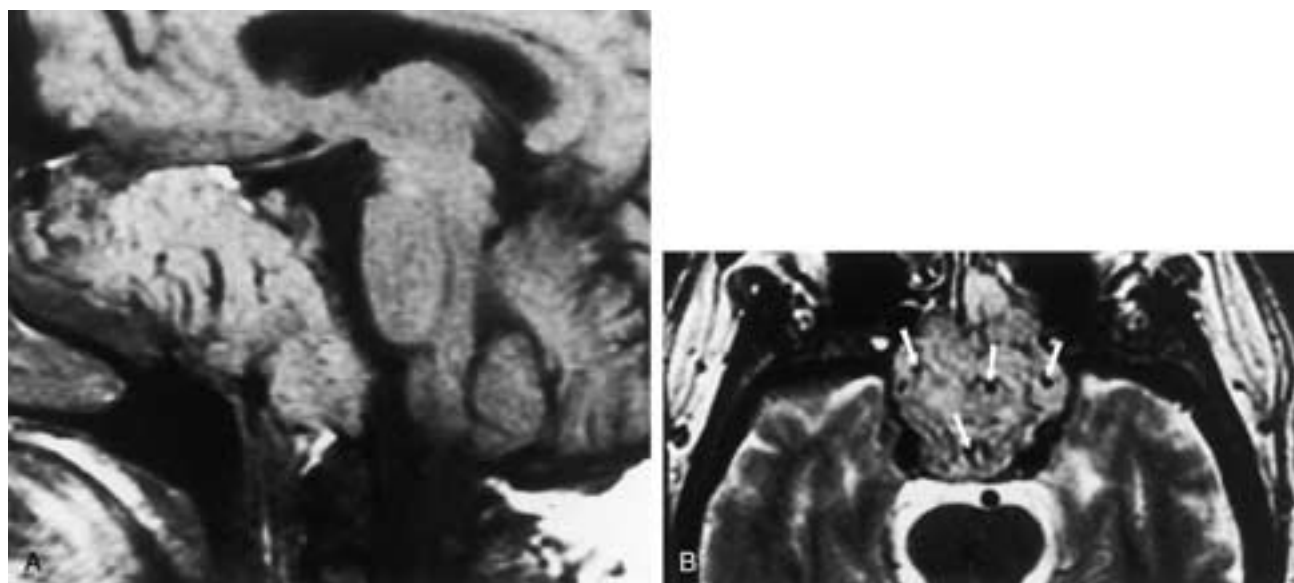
Metastatic papillary thyroid carcinoma. A, Unenhanced sagittal T1-weighted MR image shows a hypervascular (note the flow voids) metastasis to the clivus. B, Axial fast spin-echo T2-weighted MR image shows the clival mass with prominent flow voids (arrows).
